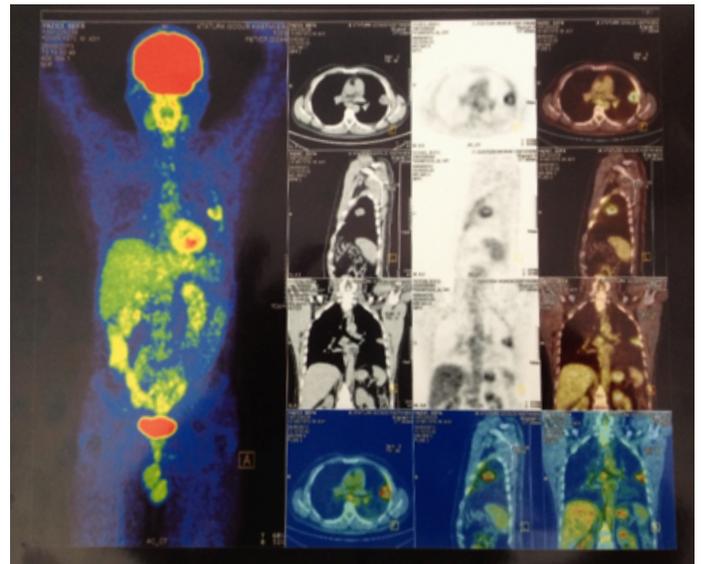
The bigger one 3 cm in size with both lungs with increased FDG uptake [SUVmax: 14.95]. Bilateral nasal cavities showed metabolic uptake images (SUVmax: 16.95). Also in the right posterior segment of palate showed increased FDG uptake (SUVmax: 16.95) (Patient only had fusion image).
